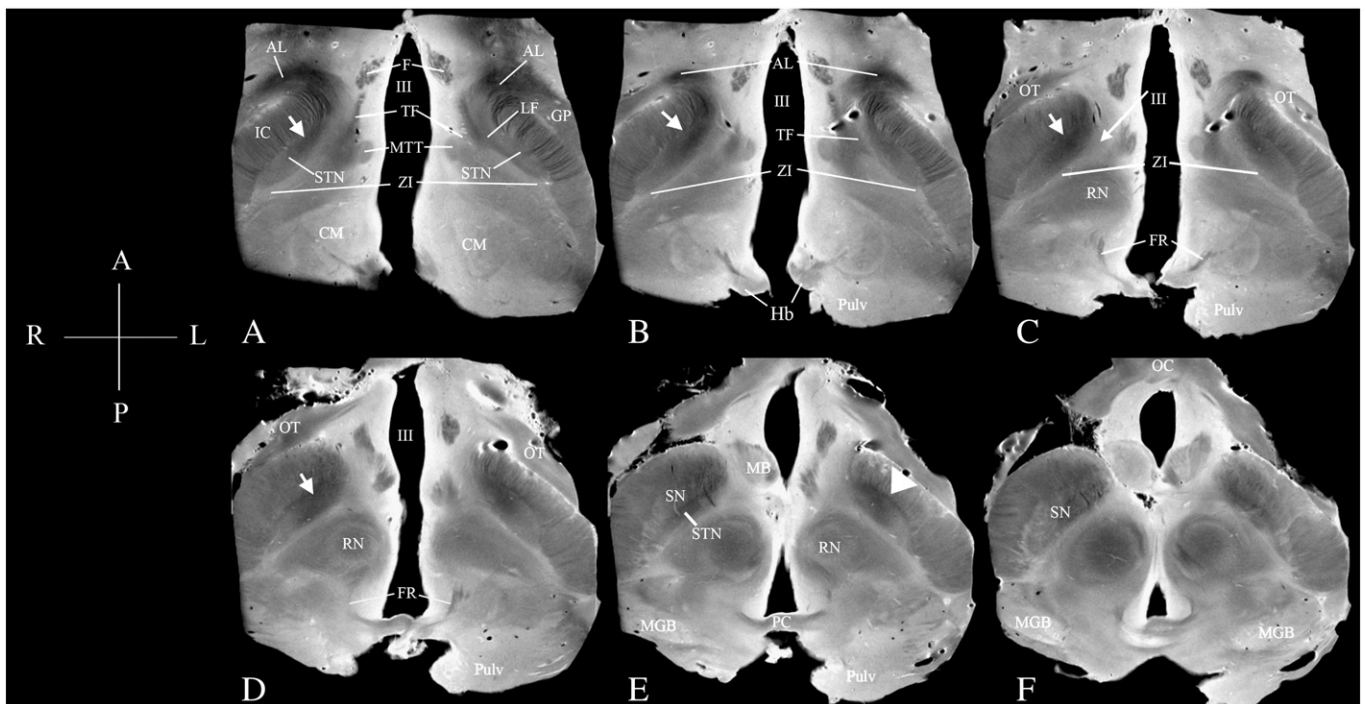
Axial Plane. The anatomy of the STN on SE MRI at 9.4 T showing both halves of the midbrain in serial axial sections from superior to inferior levels [A–F]. Long white arrow: anteromedial border of the STN defined by the confluence of the ZI and posterior border of the hypothalamus. Short white arrow: medial hypointensity of the STN (seen in 6/9 subthalamic nuclei studied). Arrow head in 2E identifying the hypointense band forming the anterior border of the STN and enabling discrimination from the SN at more inferior levels—see 2E on the right side the most inferior portion of the STN can distinguished medial to the SN. Acquired with an in-plane resolution of 88 μ m. Orientation: A— anterior, P— posterior, M—medial, L—lateral.
